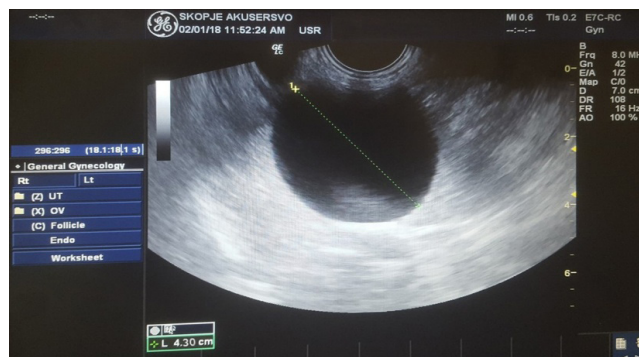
Pelvic ultrasound of the patient revealed unilocular cyst with translucent liquid.
